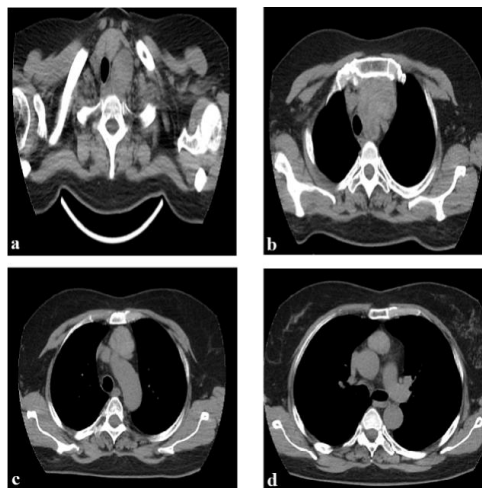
CT Images of Cervical (a), Jugular (b), Arcus Aorta (c) and Carinal (d) Levels in Giant Mediastinal Goiter
